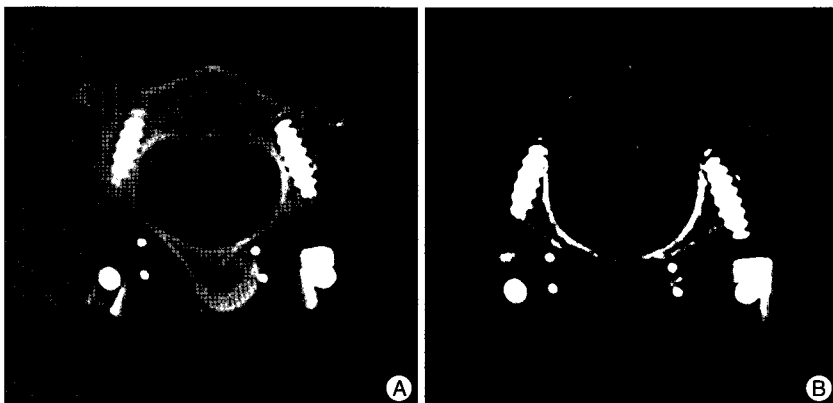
Postoperative computed tomogram scan of the C2 pedicle screw. Axial scan reveals no violation into the spinal canal (A) or the vertebral foramen (B).
